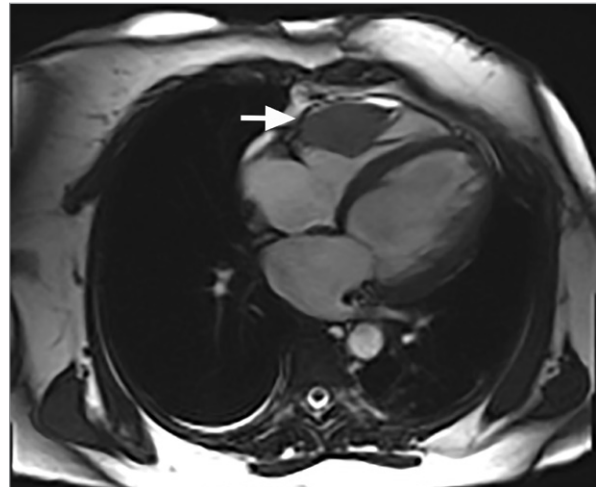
Cardiac magnetic resonance image shows a 5.6 × 2.9-cm sessile mass in the right ventricular free wall. Peripherally delayed enhancement is consistent with metastasis of the sarcoma to the heart (arrow).
